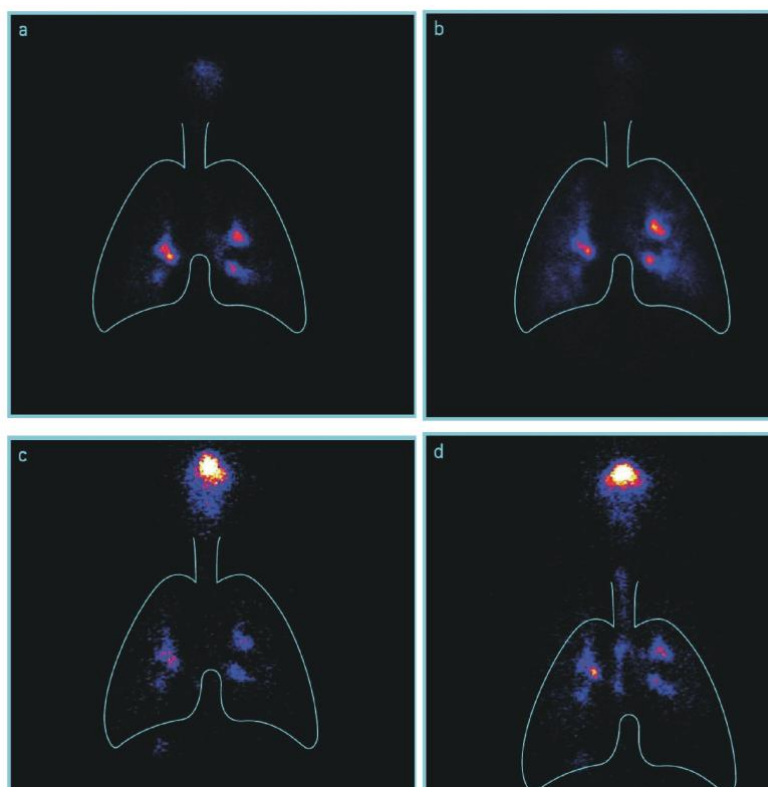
Samples of scintigraphic images from a patient showing deposition pattern from Respimat® SMI before training (a) and after training (b), and from pressurized metered-dose inhaler before training (c) and after training (d). Reprinted with permission of (Brand et al., 2008).
